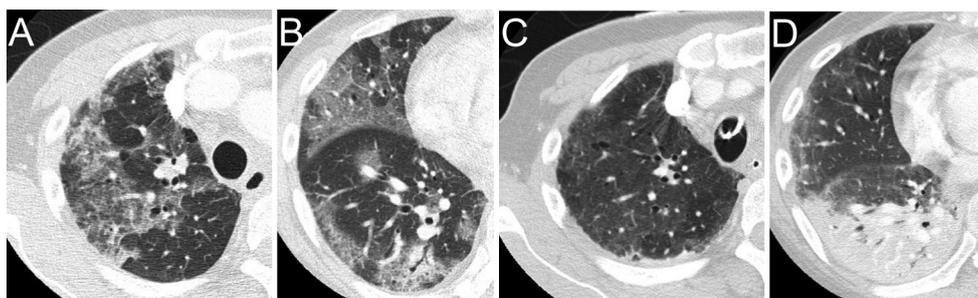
Radiological response of immune-mediated pneumonitis to infliximab. Chest CT scan on day 14 showed non-segmental diffuse ground-glass opacities consistent with immune-mediated pneumonitis (A and B). Chest CT scan on day 23 demonstrated resolution of the ground-glass opacities in the right upper lobe (C), and consolidation in the dependent part of the right lower lobe (D).
